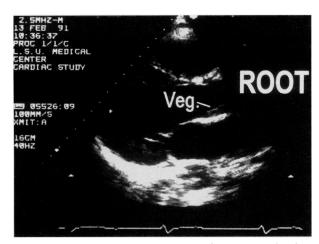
Echocardiogram showing the valvular vegetation (veg) with the aortic root (root).
